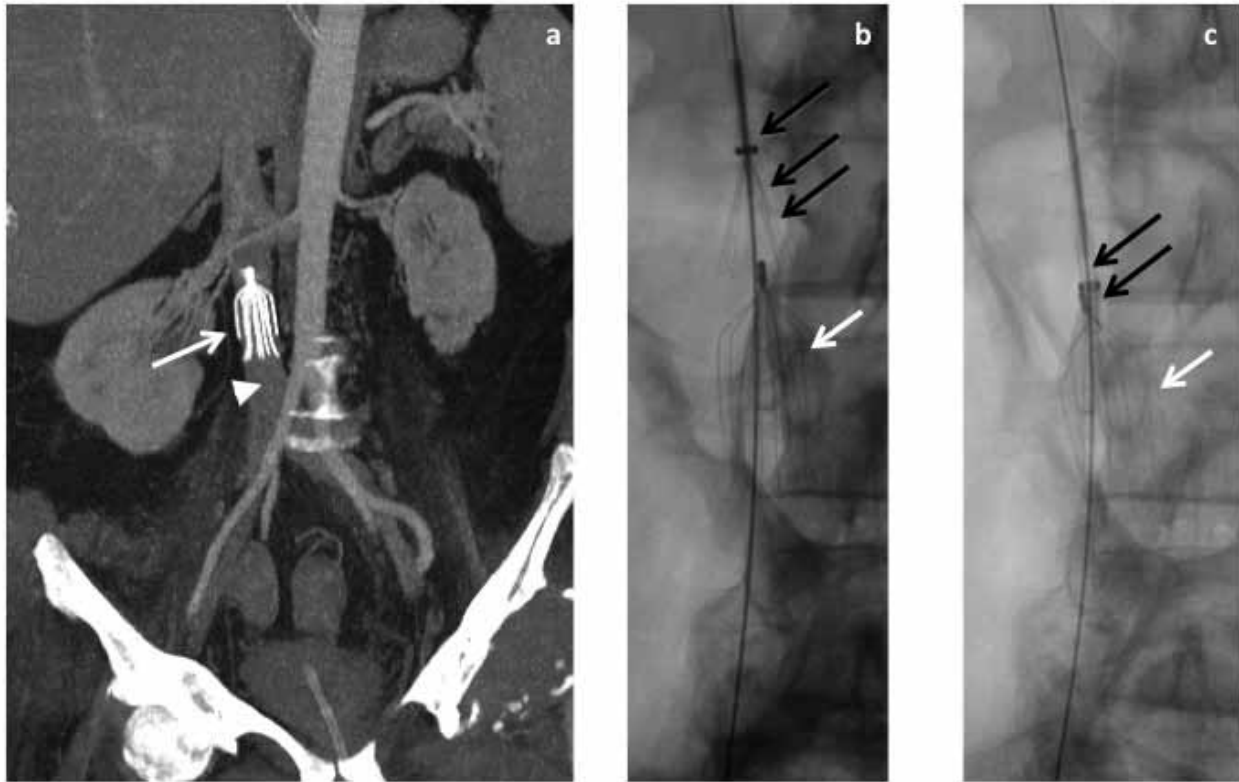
Inferior vena cava (IVC) filter placement and removal in a 45-year-old SCI patient with bleeding pressure sore and history of deep vein thrombosis. IVC filter was placed allowing anticoagulation to be stopped safely. (a) Coronal oblique maximum intensity projection (MIP) CT image shows the filter (*white arrow*) in the IVC (*arrowhead*). Once the pressure sore had improved and was no longer bleeding, anticoagulation could be commenced and the filter retrieved. (b) Fluoroscopic images of an IVC filter retrieval device (*black arrows*) being introduced into the IVC via the internal jugular vein. (c) The device then closes over the filter (*white arrow*) in order to remove it.
